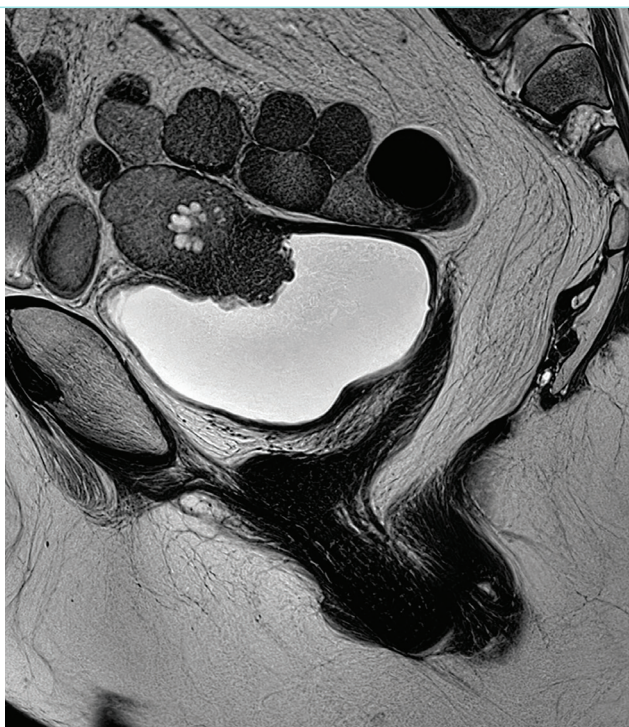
Pelvic MRI sagittal section showing a tumor invading the bladder.
